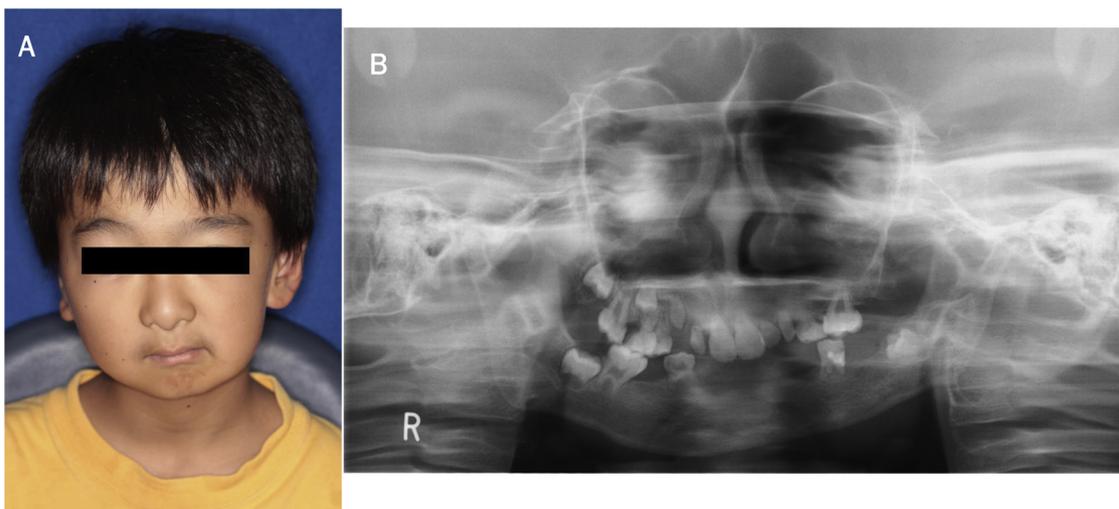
Facial photo (A) and panoramic radiography (B) 10 years after treatment. Growth insufficiency and tooth loss are present in the left lower jaw.
